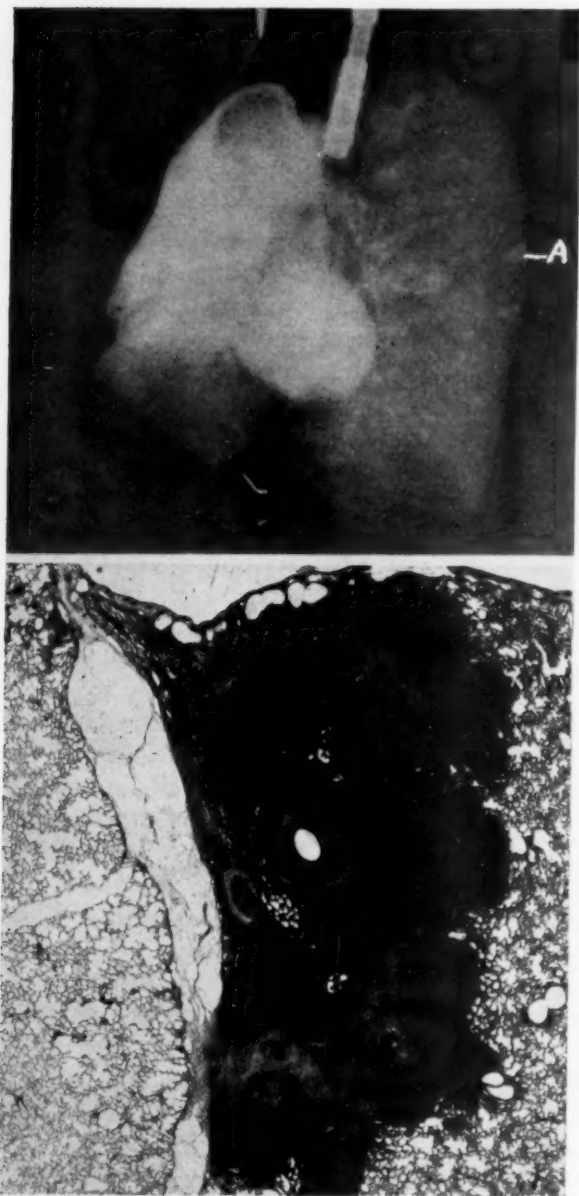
Above:* Roentgen-ray of the lungs of a case of pulmonary tuberculosis. A triangular shaped localized density seen on roentgen-ray lung films indicating caseation.
